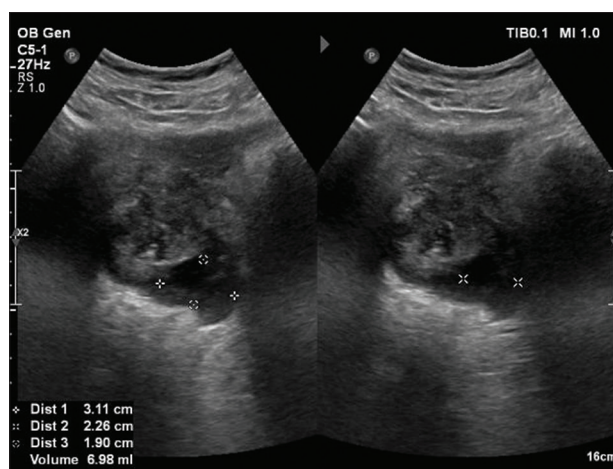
Ultrasonography abdomen showing prostatic collection
